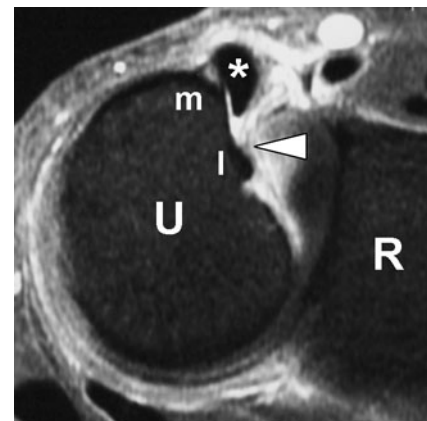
Transverse Gadolinium-enhanced fat-saturated T1-weighted spin-echo MR image (420/12) with wrist supination in a 40-year-old male patient with a type B injury of the ECU subsheath (white arrowhead). The subsheath is torn near its lateral attachment site (l) and the stump has collapsed within the ulnar groove (R radius, U ulna, m medial attachment site, * ECU tendon)
